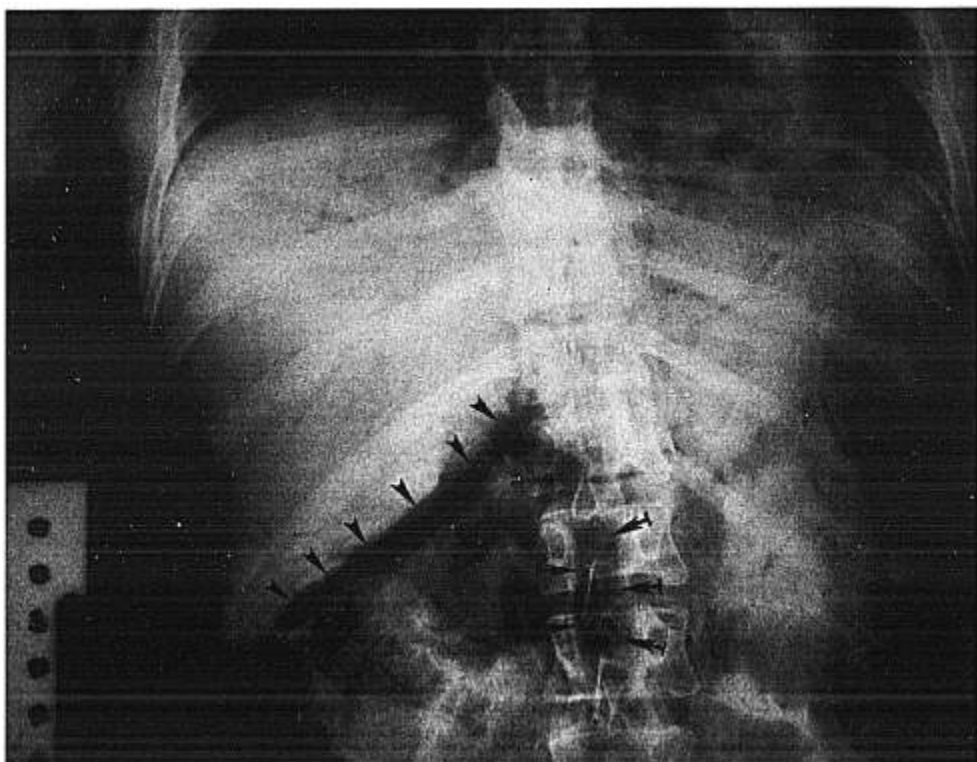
Recumbent anterior-posterior x-ray view of the abdomen shows free air in the subhepatic region (arrowheads). An air-filled large vascular structure, indicated by the tufted arrows, represents the inferior vena cava or the aorta, which may be superimposed at this level.
